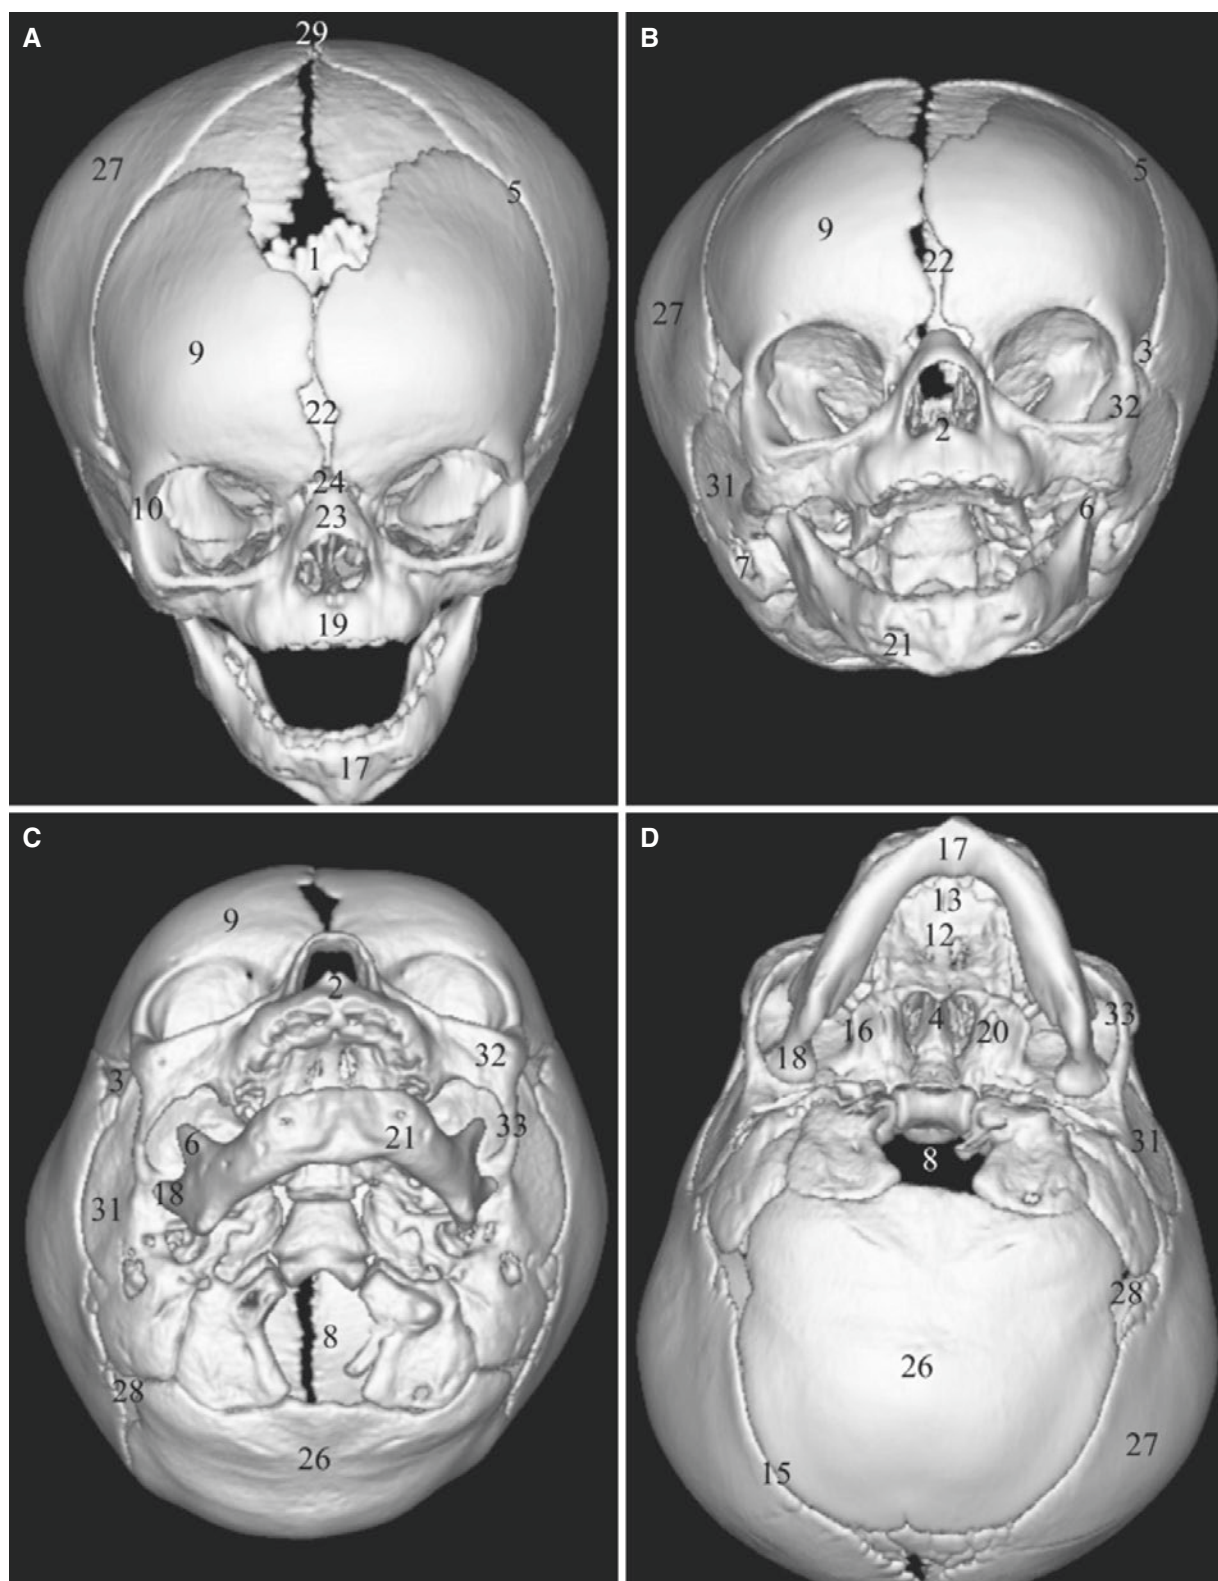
Normal bone anatomy of the face and skull; 3D CT images. (A–E) 7-month-old, (F–H) 8-year-old
